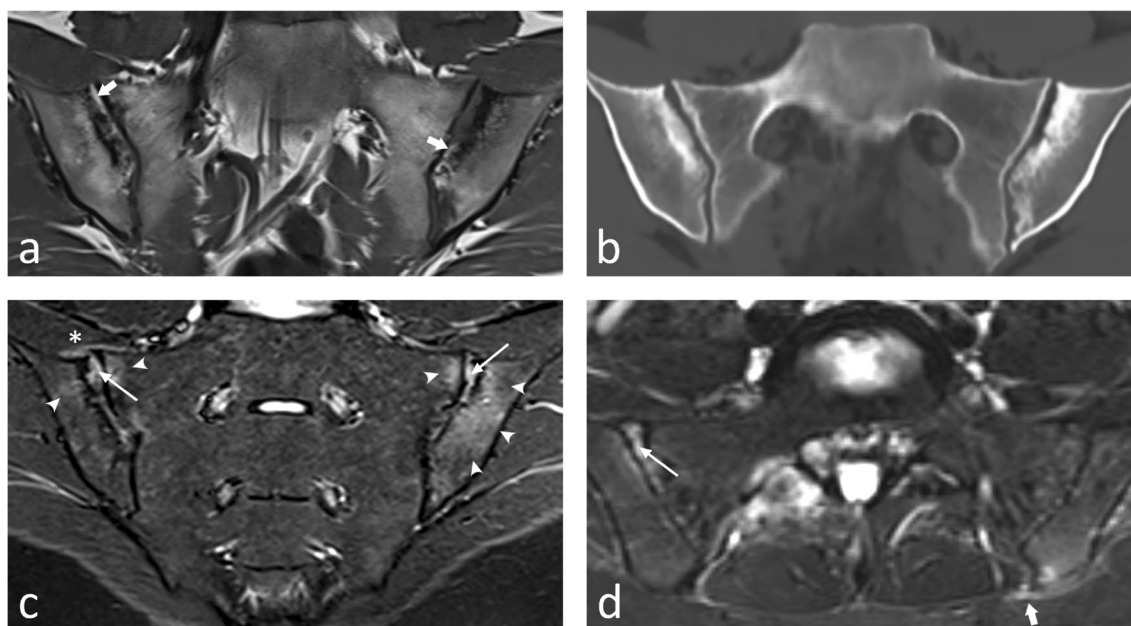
MRI of the sacroiliac joints of a 25-year-old woman with chronic inflammatory lumbar pain demonstrating both active and structural lesions. a Coronal oblique T1-weighted spin echo image and (b) coronal oblique synthetic CT (sCT) image allow detection of structural lesions including extensive erosions and adjacent sclerosis along the subchondral bone on both iliac sides and the right sacral side (better seen on sCT), with T1 hyperintense areas of fat metaplasia in erosion cavities (also known as backfill) (arrows). c Coronal oblique and (d) axial short tau inversion recovery images depict bilateral areas of subchondral bone marrow edema (arrowheads), bilateral intra-articular fluid (long arrows), capsulitis of the right sacroiliac joint (asterisk), and left-sided enthesitis of the posterior sacroiliac ligaments (short arrow)
